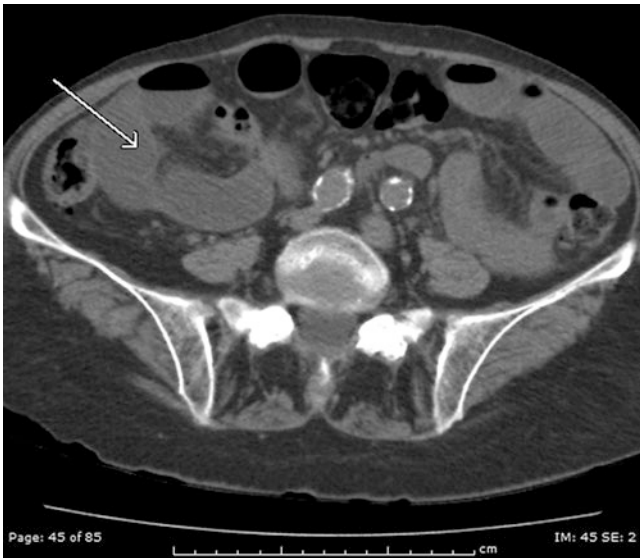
Axial CT view showing the closed loop obstruction
